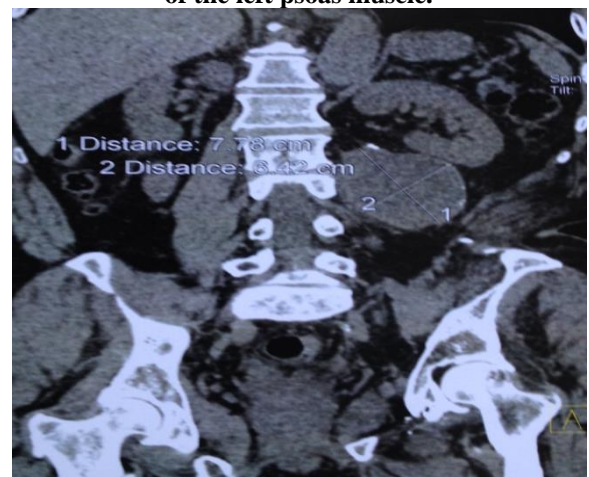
Abdominal CT with coronal sections showing the cyst with its anatomical neighborly relations.
